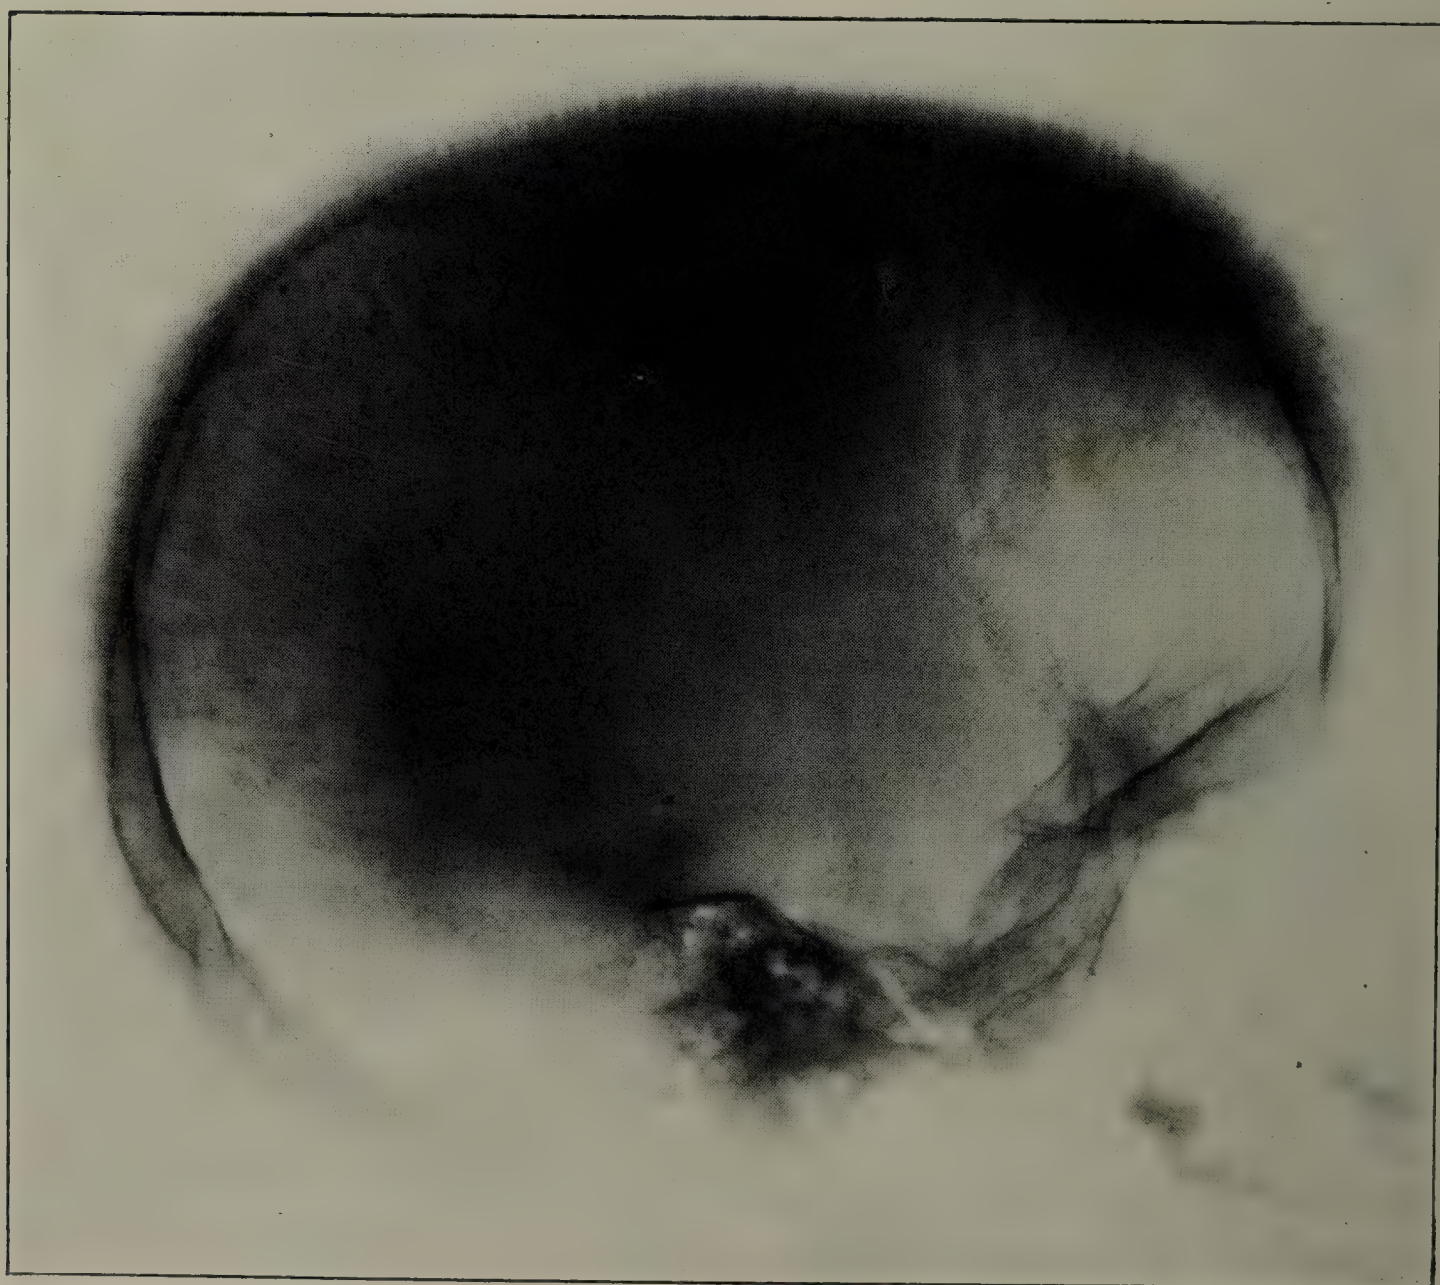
ROENTGENOGRAM OF SKULL IN PRIMARY ERYTHROBLASTIC ANEMIA.
